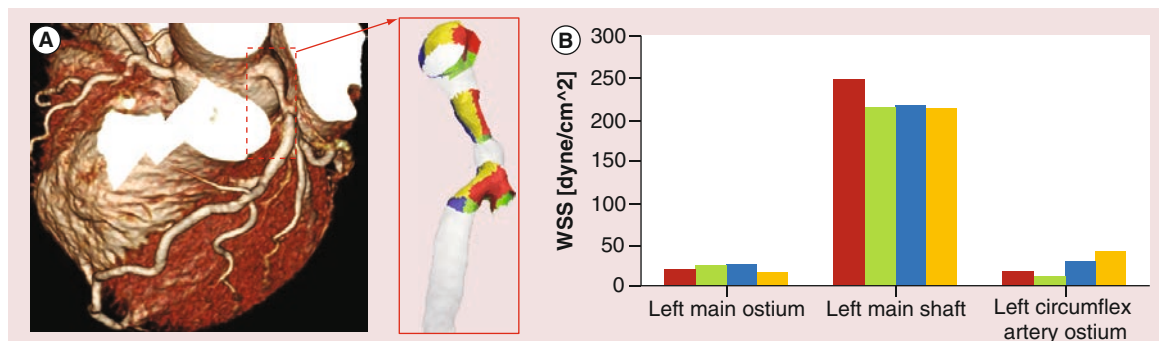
An example of segmental wall shear stress measurement using coronary computed tomography angiography. (A) A color-coded 3D map based on cCTA image demonstrates the distribution of WSS in the left coronary artery. (B) The quantification of segmental WSS shows the difference in the magnitude and distribution of WSS according to the portion of the left main coronary artery. cCTA: Coronary computed tomography angiography; WSS: Wall shear stress.
